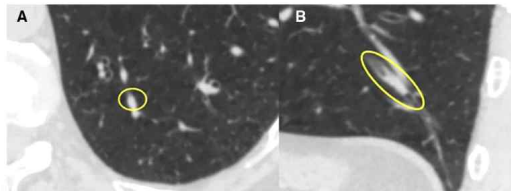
Example of a mucus plug on chest computed tomography imaging. Computed tomography axial (A) and sagittal (B) sections showing a mucus plug (encircled) occluding the lumen of an airway in the left lower lobe of a COPDGene (Genetic Epidemiology of COPD) participant with COPD. COPD = chronic obstructive pulmonary disease.
